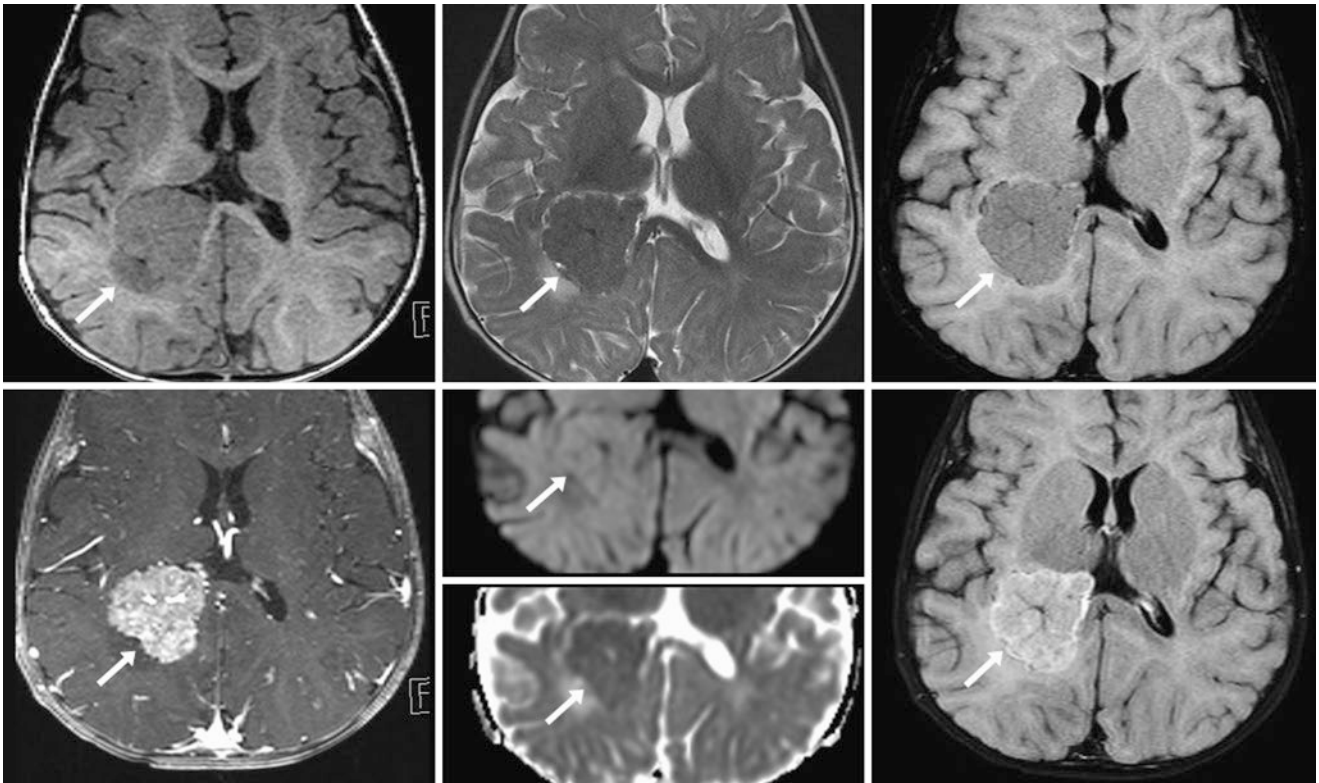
Comparison case of choroid plexus papilloma. A 7 month old with a mass (*arrows*) within the atrium of the right lateral ventricle on MRI T1WI (*top left*), T2WI (*top middle*), and FLAIR (*top right*). It
